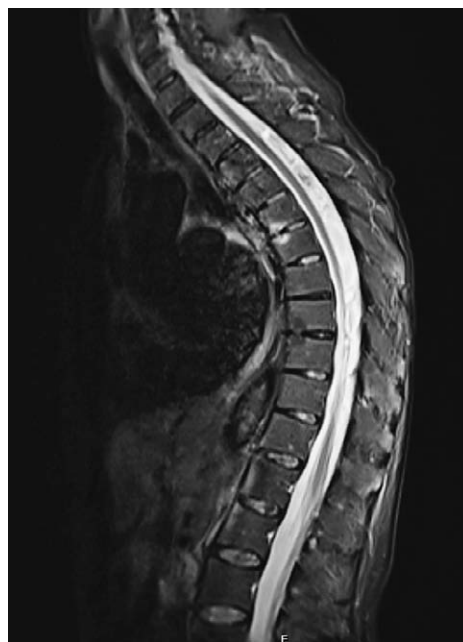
MRI of thoracic spine on T2 STIR sagittal sections. Anterior spondylitis of Th5/Th6 level (Romanus lesion), and chronic lesion at the Th8/Th9 level (chronic Romanus lesion)
